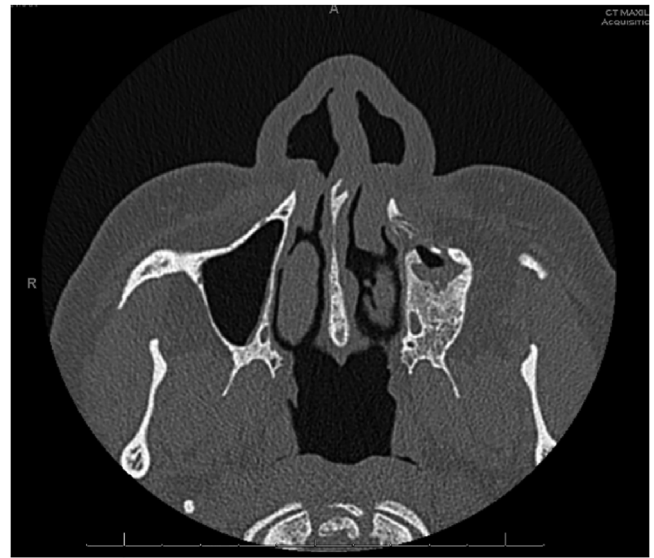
CT of the sinuses without contrast: Chronic left maxillary sinusitis with associated erosion of the anterior/inferior wall of the left maxillary sinus as well as the left maxillary alveolar ridge and hard palate. There is focal defect at the floor of the left maxillary sinus. There is mild soft tissue prominence anterior to the left alveolar ridge, overlying the area of osseous erosion, without evidence for drainable fluid collection.
